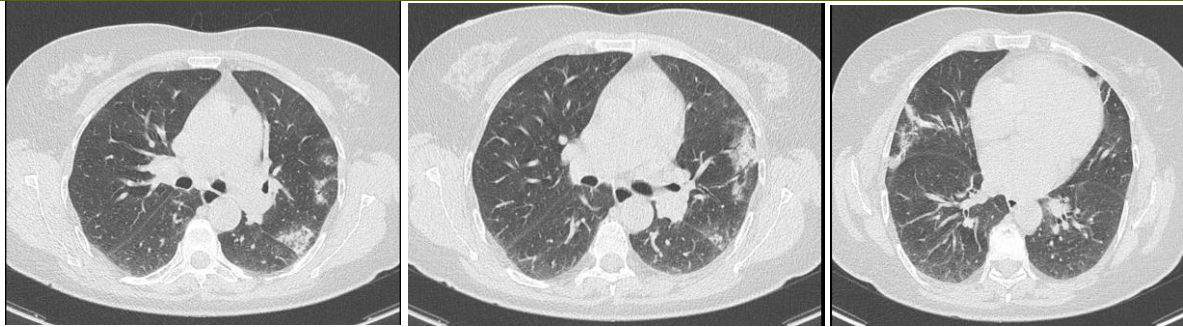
Thoracic imaging demonstrating a bilateral interstitial syndrome with basal predominance. Computed tomography (CT) of the chest reveals ground-glass opacities associated with bilateral areas of consolidation, more pronounced in the upper lobe (culmen) and lingular segments, suggestive of an infectious etiology.
